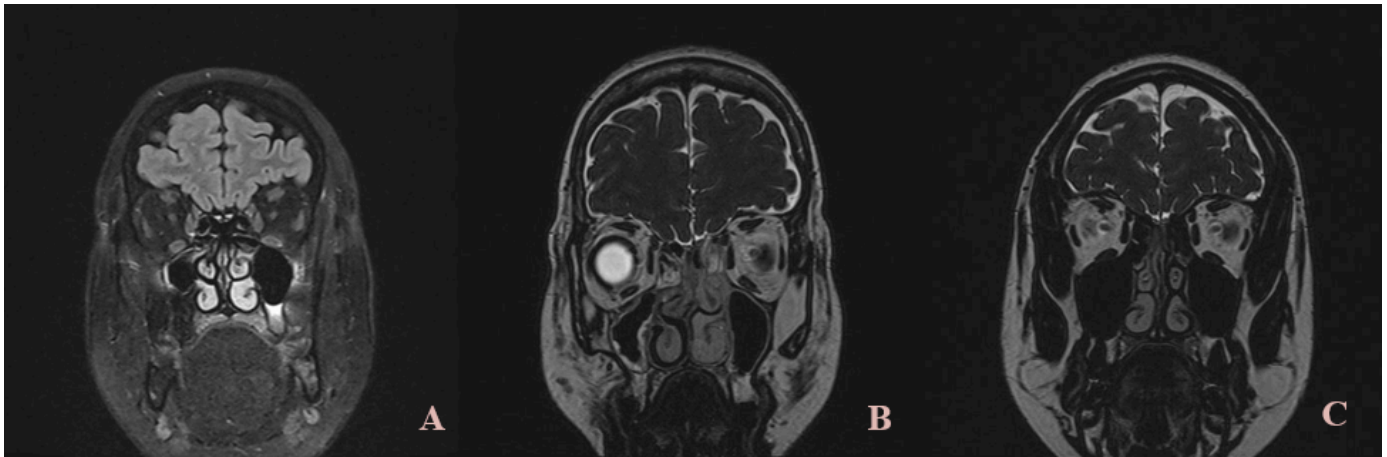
MRI alterations in evaluated patients. A: bilateral neuropathy, B: unilateral thinning of the olfactory bulb, C: asymmetrical decrease in the size of the olfactory bulb.)
